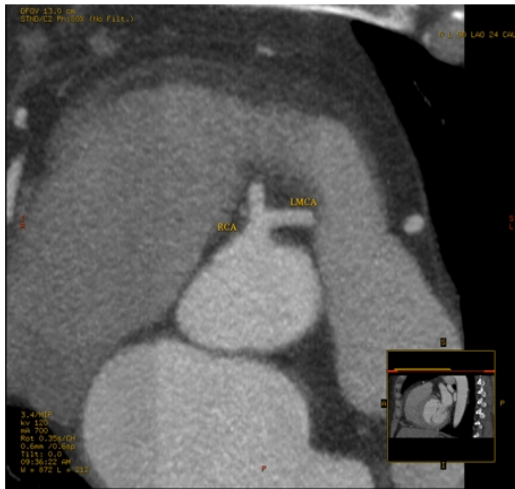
Coronary CTA showing shared trunk of RCA and LMCA.
